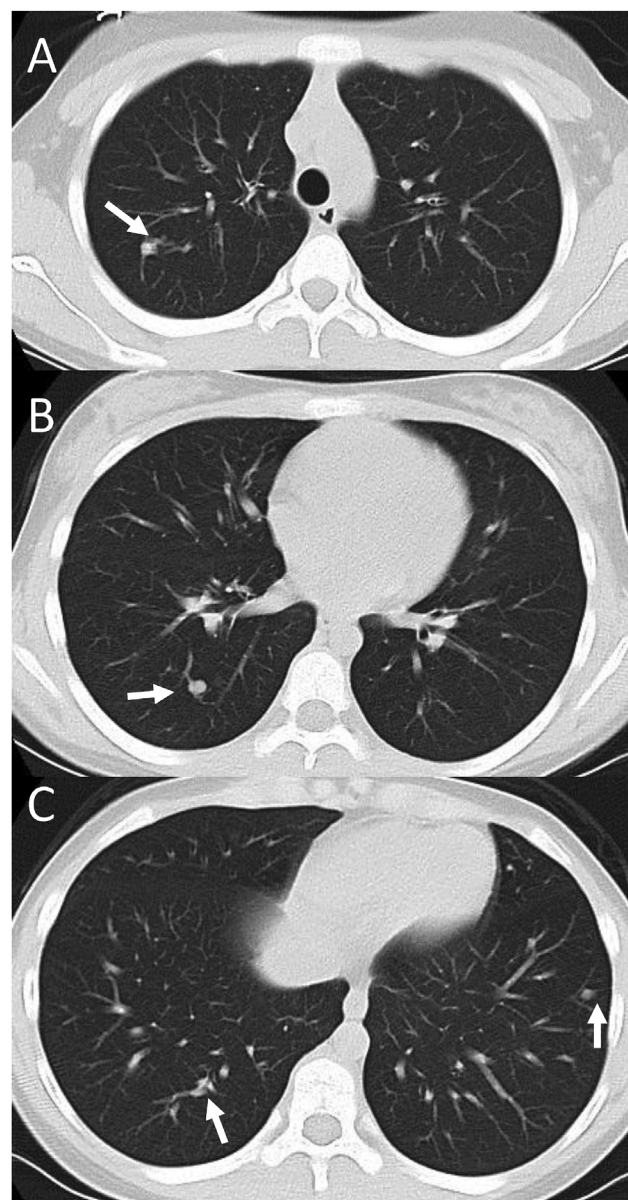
Case 4. Chest CT shows three PAVMs (arrows) in right upper lobe (A), lower lobe (B) and left lower lobe.
